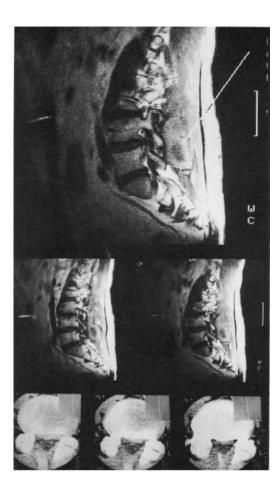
Nonmetallic foreign body within the muscles after lumbar disk surgery. MRI demonstrates the foreign body, whereas CT (performed by Radiological Institute Dres. Kaesbach/Wierer, Kiel) failed to do so
